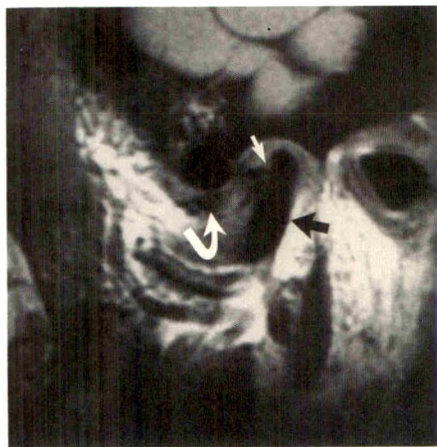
Extensive avascular necrosis, osseous deformity, condylar defect compatible with unstable osteochondritis dissecans, and advanced internal derangement of temporomandibular joint in 37-year-old woman with 10-month history of temporomandibular joint pain, locking, and acquired occlusal deficit. Sagittal MR image, 600/20, shows complete absence of marrow signal from both condyle and condylar neck (black arrow). Large articular surface defect (straight white arrow) is observed with late-stage meniscus (curved arrow) derangement. Surgery, 7 months after imaging, revealed depressed, pitted articular surface with partial resurfacing of condyle by fibrous tissue.
